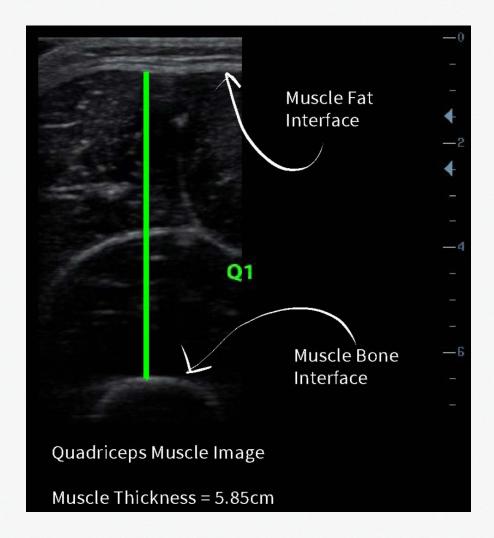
displays a B-mode ultrasound image of the quadriceps muscles. Within the image, the muscle fat interface and the muscle bone interfaces are labeled. The Green line represents how muscle thickness is measured (from interface to interface). The biceps image provided is a female biceps with a thickness of 3.44cm.
